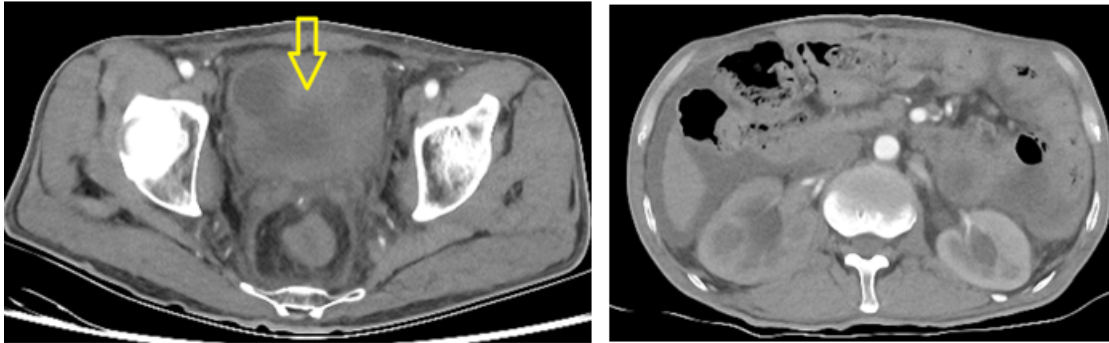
Axial CT images of the patient: A) CT scan has demonstrated diffuse irregular thickening of the bladder wall. B) Bilateral renal pelvicalyceal structures appear moderately dilated in this CT scan.
